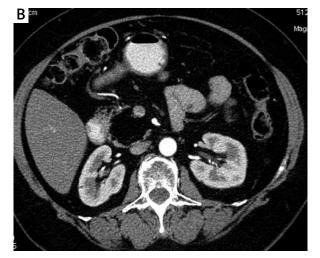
Contrast-enhanced CT. A hypodense homogeneous tumour, consistent with fat density (see A before contrast IV injection). The lesion is poorly vascularized (see B and C showing arterial and portal venous phases, respectively). The tumour is encapsulated and surrounded by normal pancreatic tissue. It is adjacent to the superior mesenteric vessels
